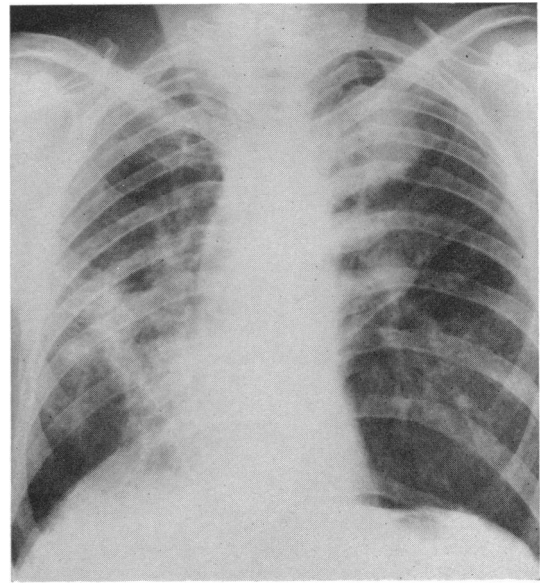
Case 3. Radiograph of chest, November, 1949, showing clearing of mottled shadows at time of appearance of tuberculin sensitivity and of tubercle bacilli in sputum.
